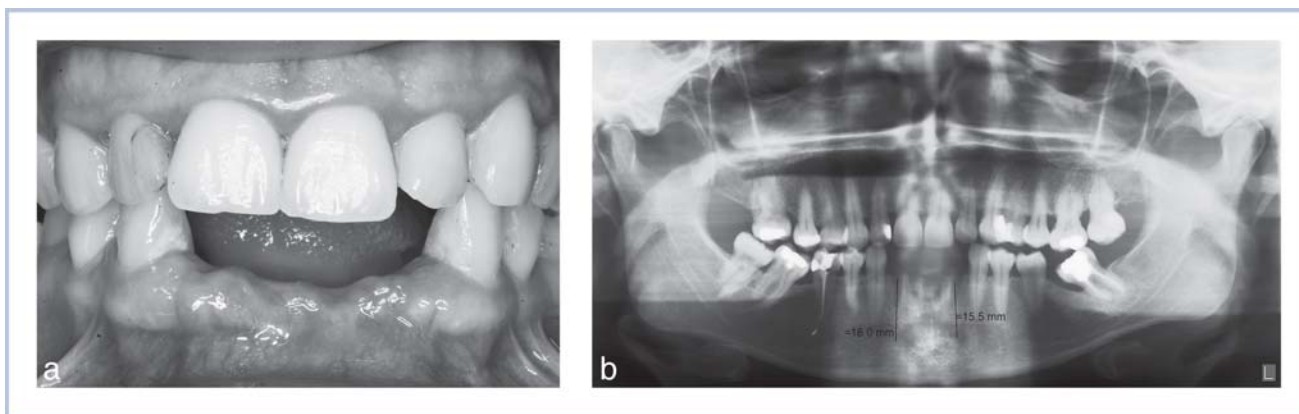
(Case 1) (a) Clinical image showing significant bone atrophy in the mandibular incisor zone. (b) Preoperative radiograph.
